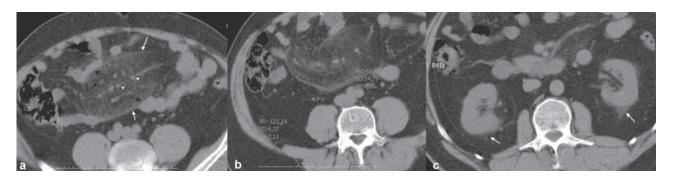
a. Mesenteric panniculitis. Axial CT image midabdomen shows a well-defined, inhomogeneous fatty mass with a hyperattenuating peripheral rim (white arrow). The mass lateral displacement of the bowel loops (black arrow), mesenteric vessels (arrowhead) and some small nodules (curved arrow); b. The density of the mass is higher than that of the retroperitenoal adipose tissue; c. Perirenal space is heterogeneous (arrow), with mixed fat and soft density tissues.
